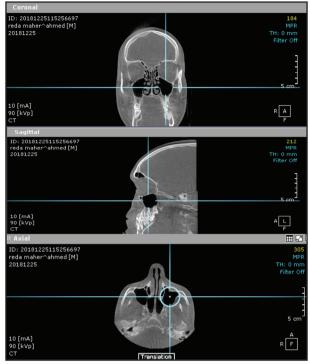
Cone beam computed tomography; translation to the maxillary sinus of one side in coronal, sagittal and axial views.
